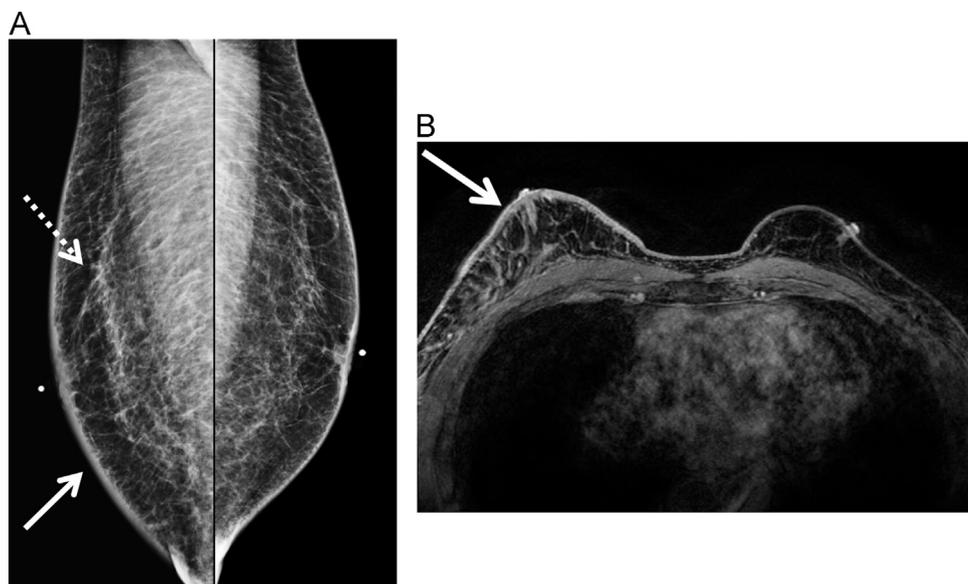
A 66-year-old male presents with a clinical diagnosis of right breast inflammatory breast cancer. The work-up started with diagnostic mammography. Bilateral MLO views (A) demonstrate diffuse skin (solid arrow) and trabecular thickening (dotted arrow) in the right breast, consistent with the clinical diagnosis of inflammatory breast cancer, without evidence of a primary breast mass. Axial T1-weighted fat suppressed postcontrast MRI (B) shows diffuse skin and trabecular thickening and enhancement in the right breast (solid arrow), corresponding to the mammographic findings and in keeping with clinical diagnosis of inflammatory breast cancer. No primary breast mass was seen on MRI.
